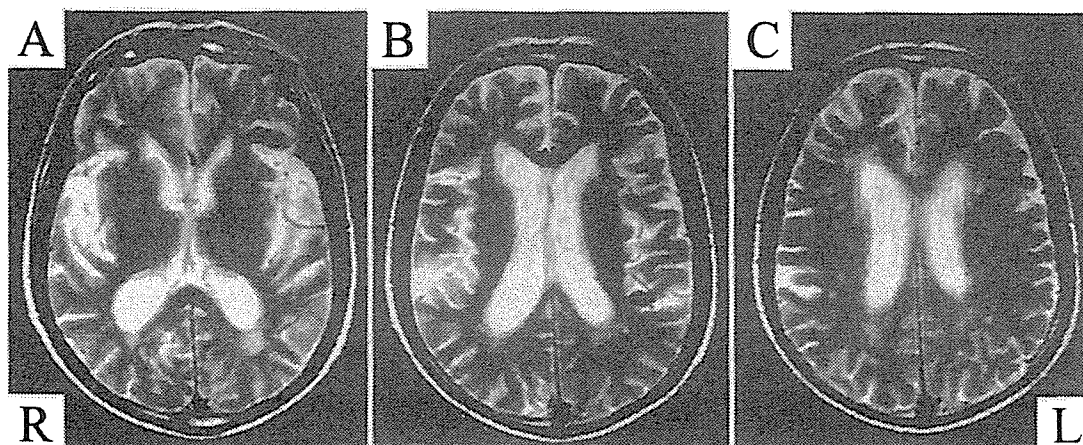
Case 1. Axial T₂-weighted MR images obtained at admission, showing small areas of high signal intensity in the bilateral corona radiata. L = left; R = right.
